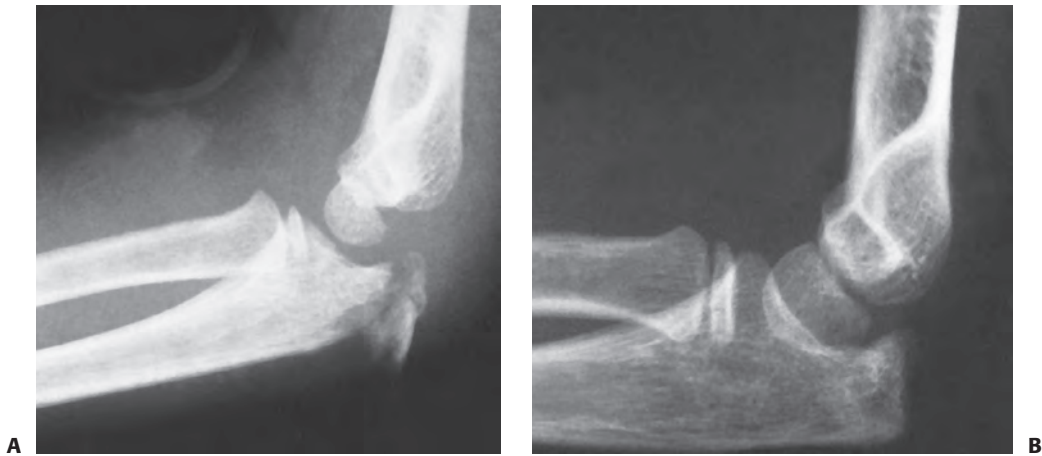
Preosseous apophyseal arrest. A: Comminuted fracture of the proximal olecranon from a direct blow to the elbow in an 8-year-old male. This fracture was treated nonoperatively. B: Radiograph 18 months later shows cessation of the proximal migration of the metaphyseal margin and a lack of development of a secondary ossification center. Despite this arrest of the apophysis, the patient had a full range of elbow motion.
